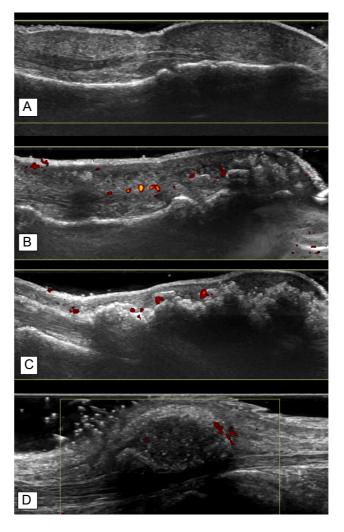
Examples of ultrasound images without and with calcinosis in various forms.
